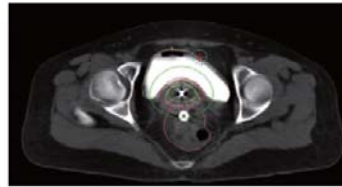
CT imaging of patients with applicator, high-risk clinical target volume (HR-CTV: light blue line) and Organs at risk (bladder and rectum). The 150%-, 100%- and 50%-isodose lines were shown in yellow, red and green colors, respectively.
